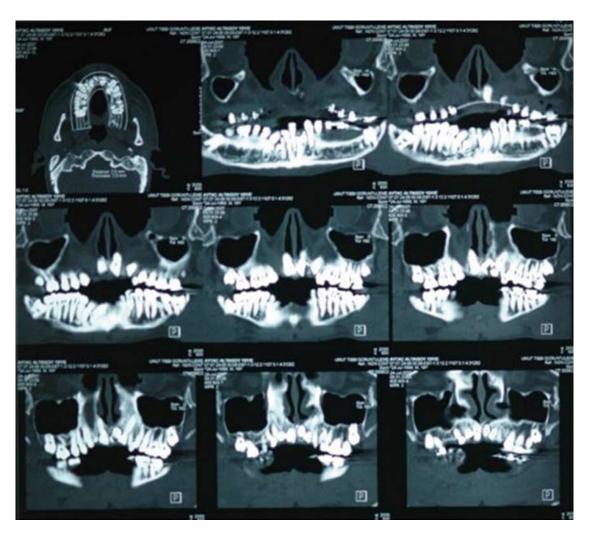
Frontal cone beam computerized tomography sections show impacted permanent and supernumerary teeth in detail.
